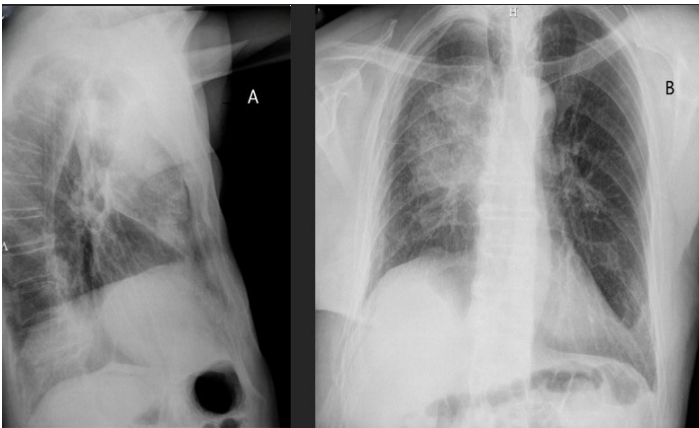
Chest X-Ray on postoperative Day 1 (A - lateral) and Day 3 (B – anteroposterior) shows increased opacification in the right upper and middle lung fields.
